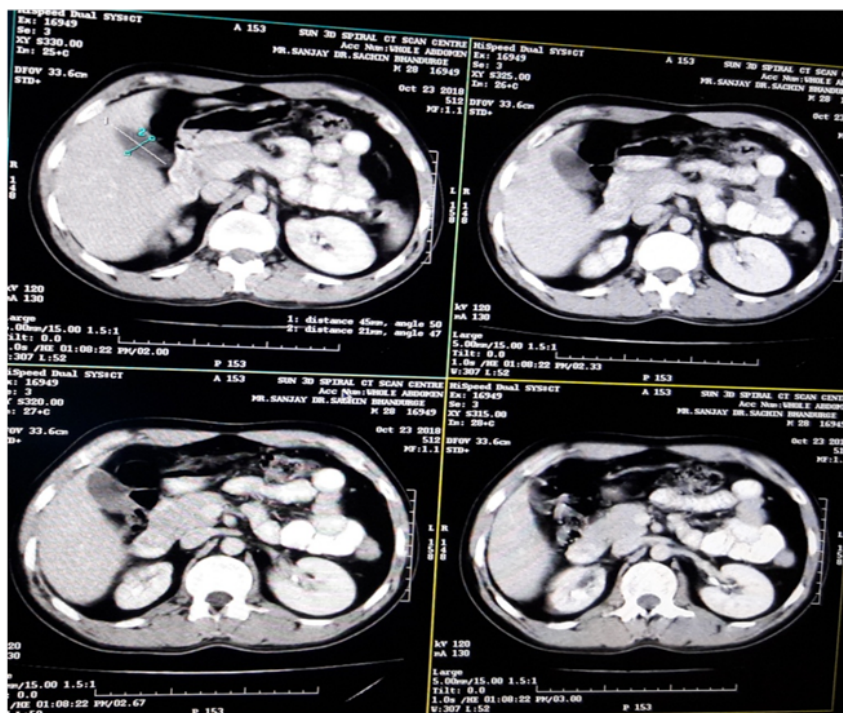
CT Scene of abdomen measuring longitudinal axis (Number 1) and Transverse diameter (Number 2) of gallbladder
